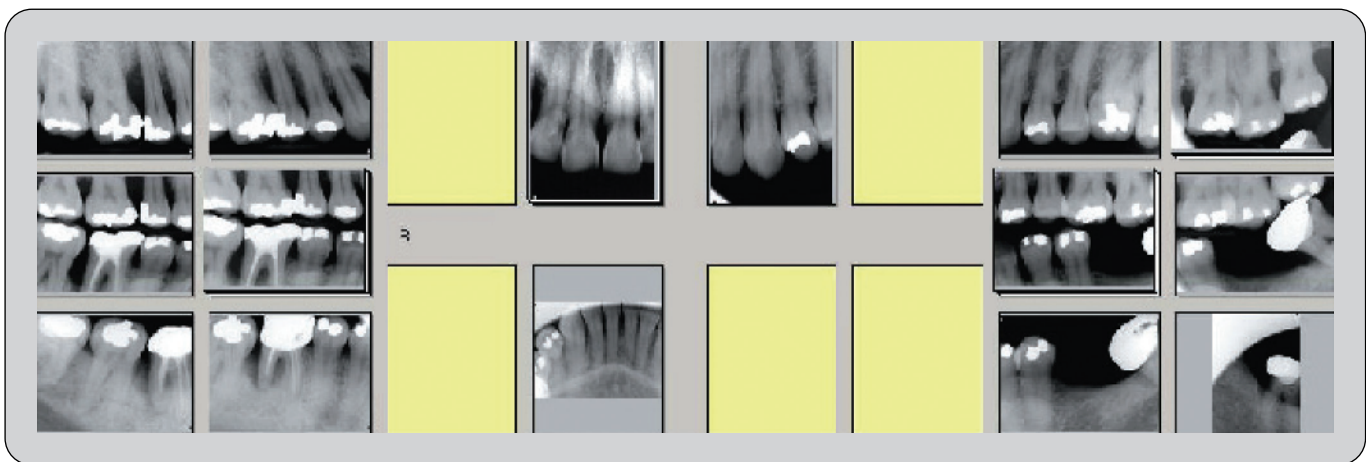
Full mouth series radiographs.
